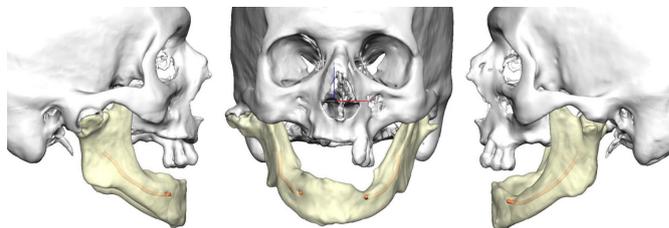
Preoperative 3D reconstruction based on a CT scan.
